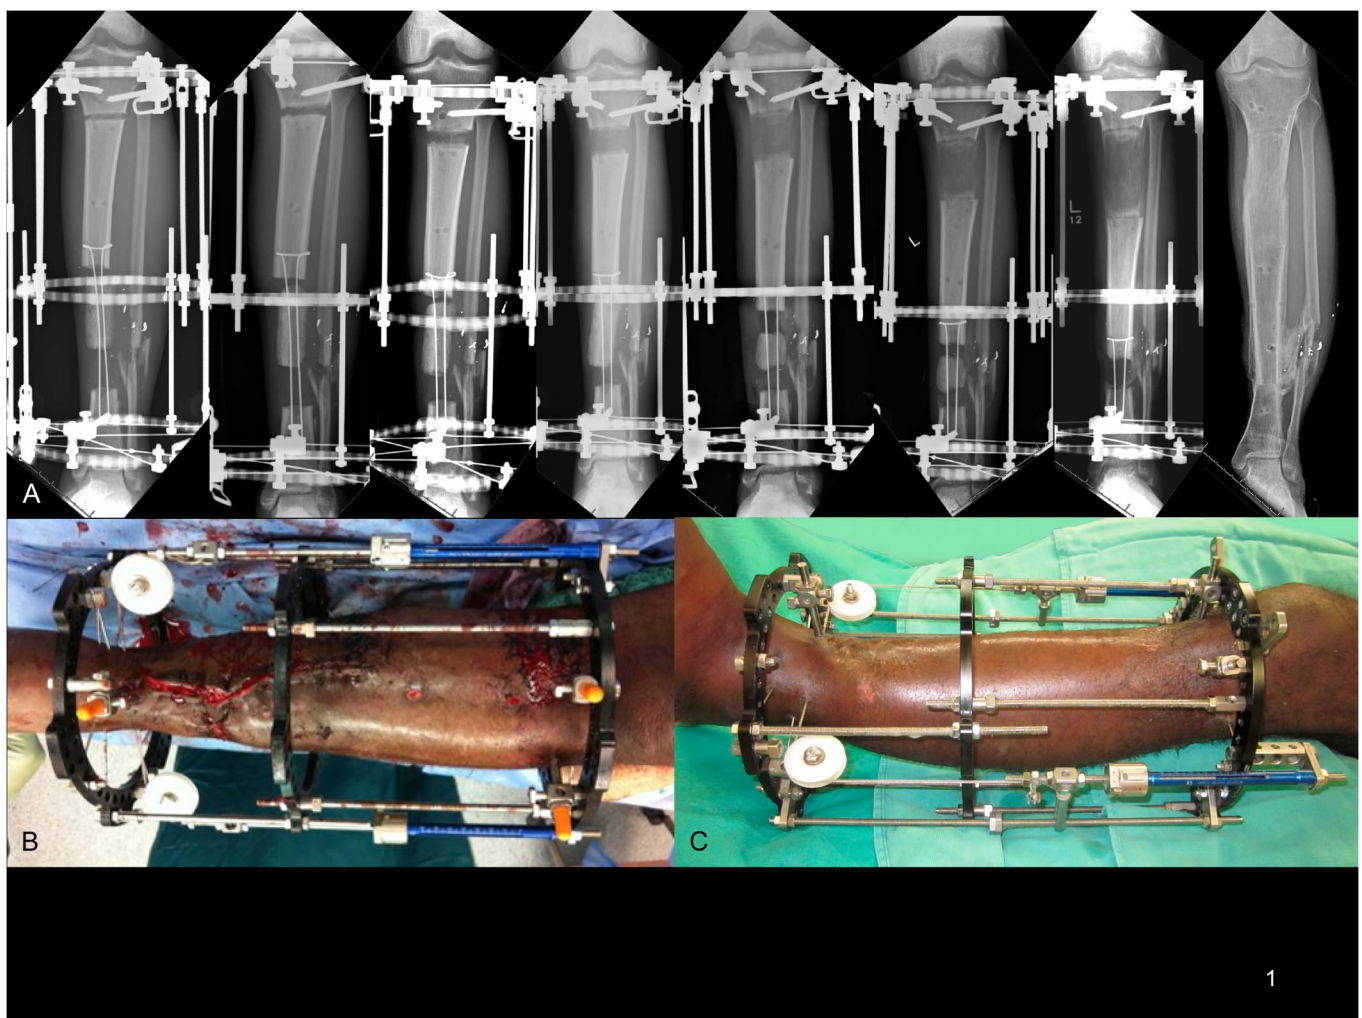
A, A 35-year-old man with a 12.7-cm defect from a high-velocity gunshot wound treated to healing in cable transport circular fixator. Radiographic series shows balanced pull of the 2 sides of the cable aims the distal end straight to the fulcrum and eliminates waggle in the transported segment. Note the progressive straightening of the transport segment and trailing regenerate column throughout transport. B, Clinical photograph of cable transport frame and leg before transport. C, Clinical photograph of cable transport frame and leg at time of healing.
